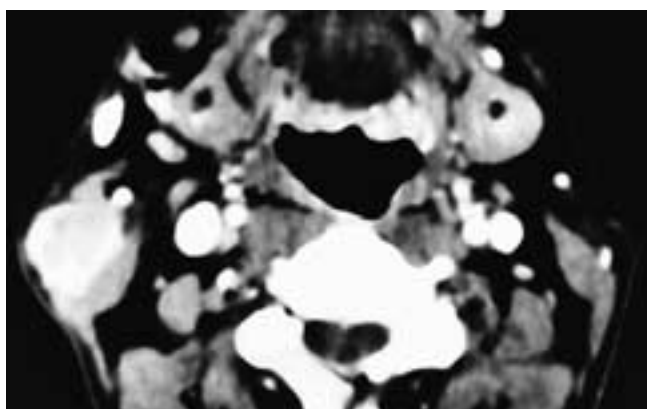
Axial contrast-enhanced CT scan shows an enhancing, benign-appearing mass in the right parotid gland. This patient had a hemangioma.
